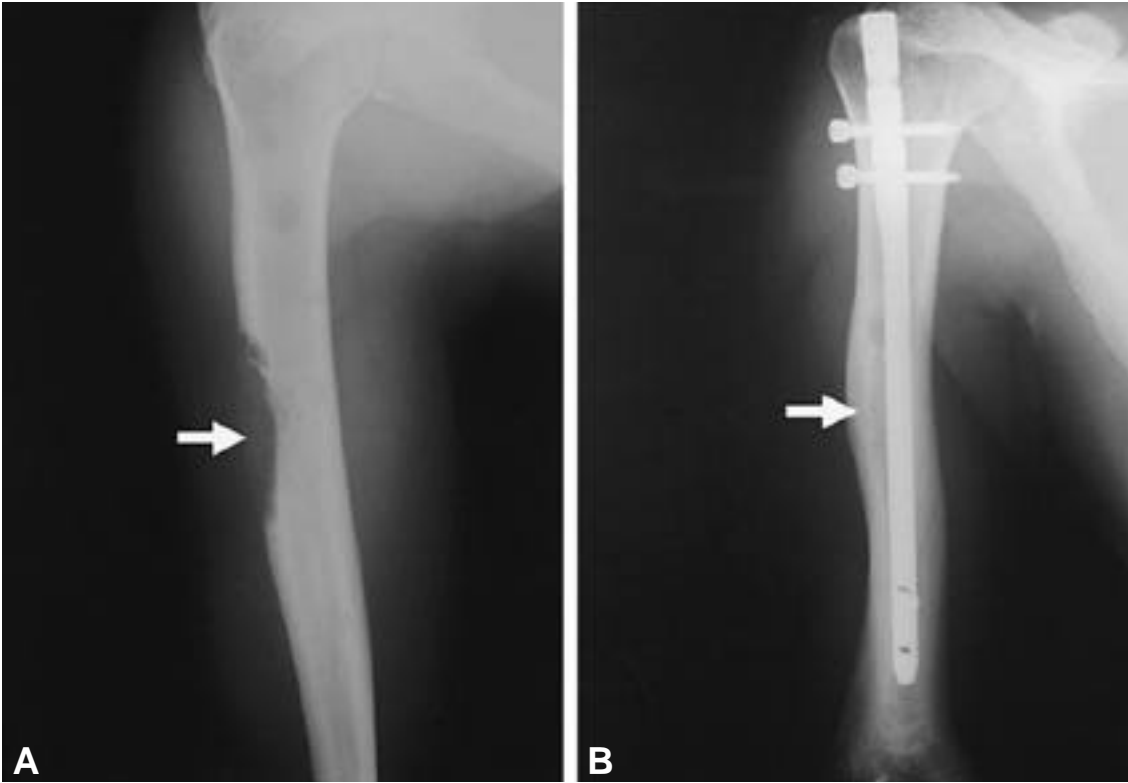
A. Plain radiograph shows a large destructive lesion involving cortex and part of medulla of shaft of humerus. The patient was 38-years old man with lung cancer for 1 month. B. Plain radiograph reveals perfect new bone formation at 1 year after surgery and postoperative radiotherapy. The final result was good both in pain relief and function recovery.
